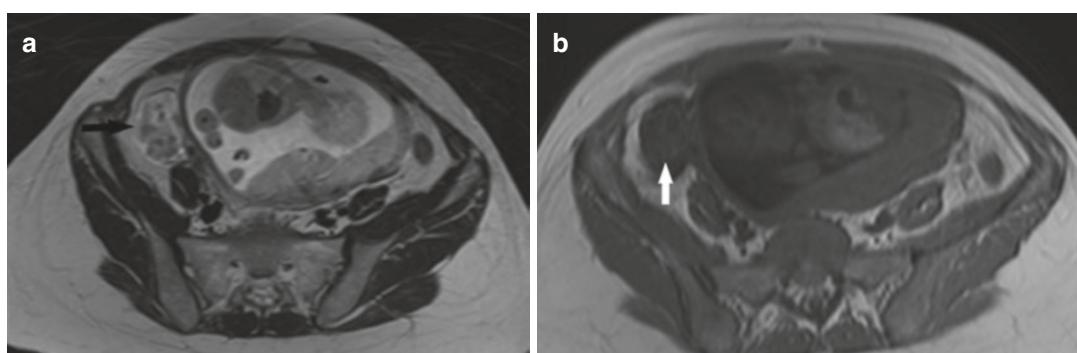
Ovarian torsion in a 30-year-old woman at gestational week 27 with acute pelvic pain. Axial (a) T2-weighted HASTE image shows an enlarged, edematous right ovary (black arrow). Axial T1-weighted MR
